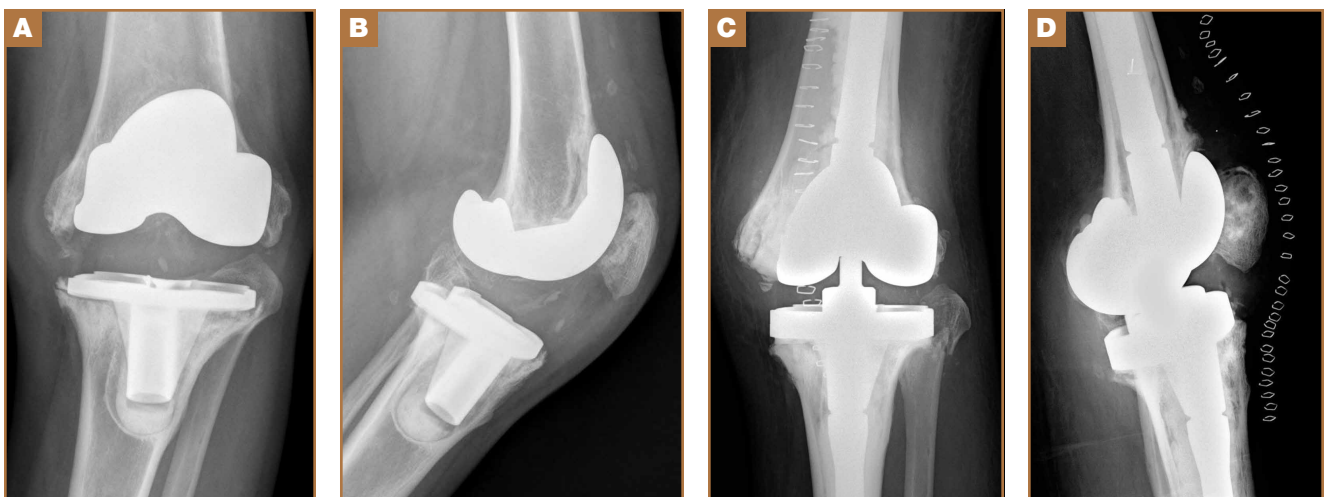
Aseptic prosthetic loosening in hemophilic patient who underwent total knee arthroplasty (TKA) (NexGen, Zimmer) with patellar resurfacing 13 years earlier. One-stage revision TKA (Constrained Condylar Knee, Zimmer): (A) Preoperative anteroposterior (AP) radiograph, (B) preoperative lateral radiograph, (C) AP radiograph after revision surgery, and (D) lateral radiograph of revision prosthesis.
